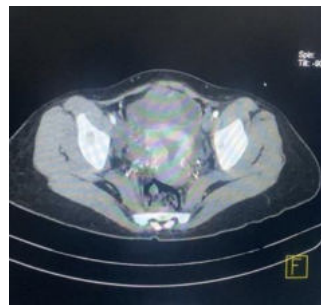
CT showing the tumour arising from right ovary – a mural
